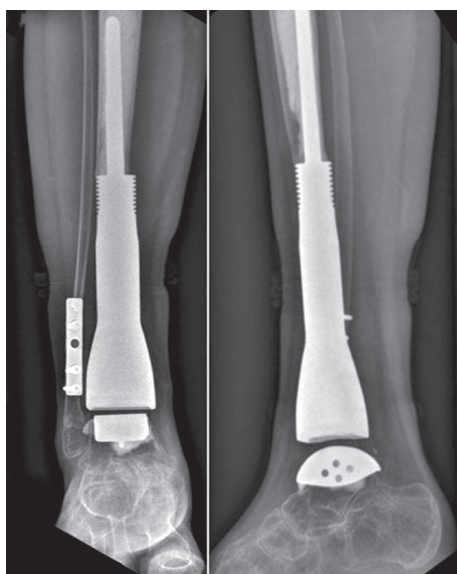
Radiographs of the ankle. Condition after arthroplasty with an oncological prosthesis (19 months after surgery) [65]
